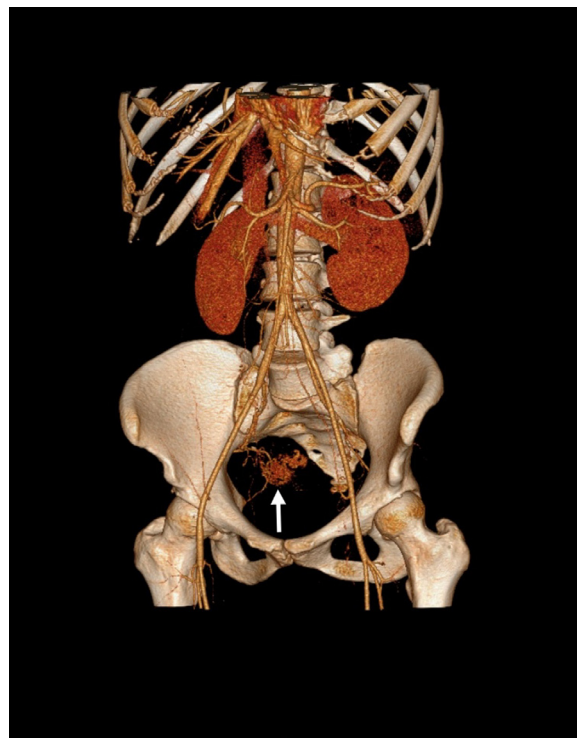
CT coronal multiplanar reformation reconstructed image showing the nidus (arrow).
